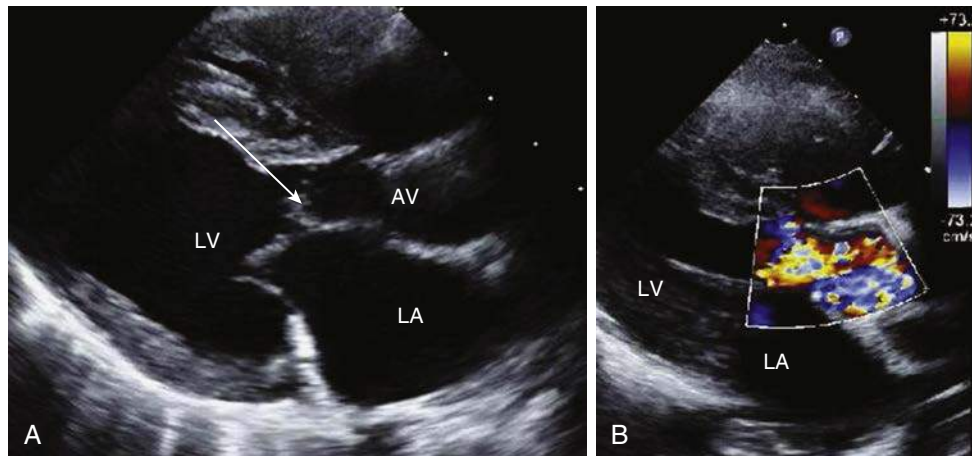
Left ventricular outflow tract (LVOT) obstruction. A, 2D Parasternal long axis view (PLAX) demonstrates LVOT obstruction caused by LVOT narrowing and what appears to be a subaortic membrane (blue arrow). B, Color Doppler of the same PLAX view demonstrates aliasing and flow acceleration consistent with significant LVOT obstruction. AV, Aortic valve; LA, left atrium; LV, left ventricle.
